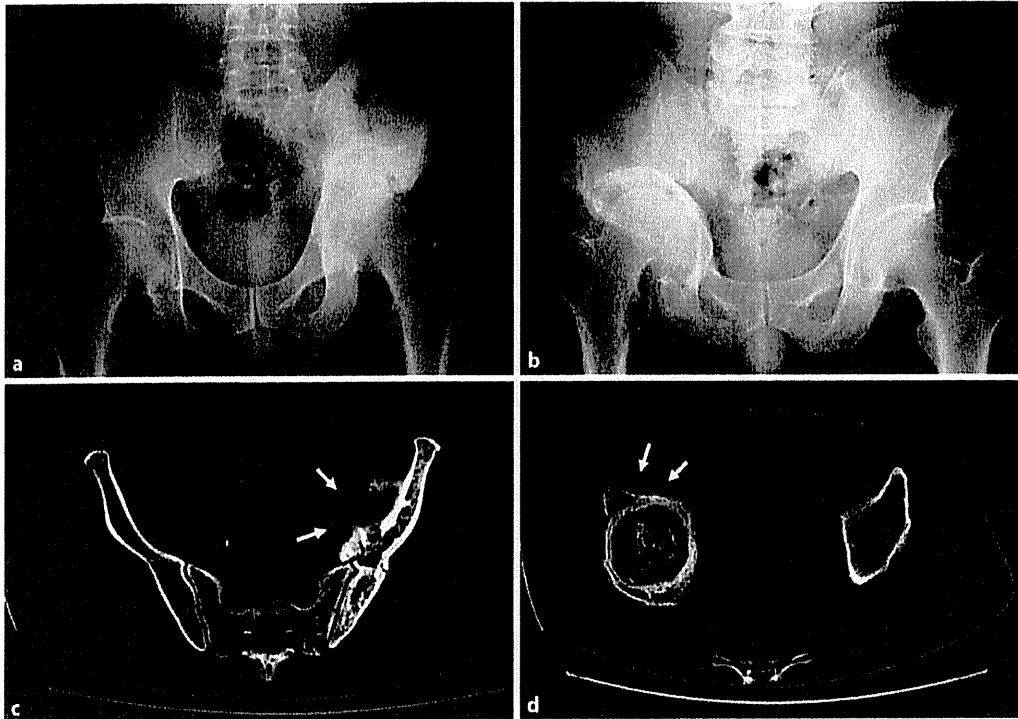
Radiographs and CT images after chemotherapy (R-CHOP). a In March 2008, radiography showed an increased osteosclerotic change and an obscure fracture line in case 1. b In February 2007, radiography showed new bone formation and increased osteosclerosis around the acetabulum as well as intrapelvic migration of the femur head in case 2. c In March 2008, CT imaging revealed increased osteosclerosis and the necrotic soft tissue mass around the affected bone lesion (arrows) in case 1. d In February 2007, CT imaging revealed the necrotic soft tissue mass around the affected bone lesion (arrows) in case 2.
